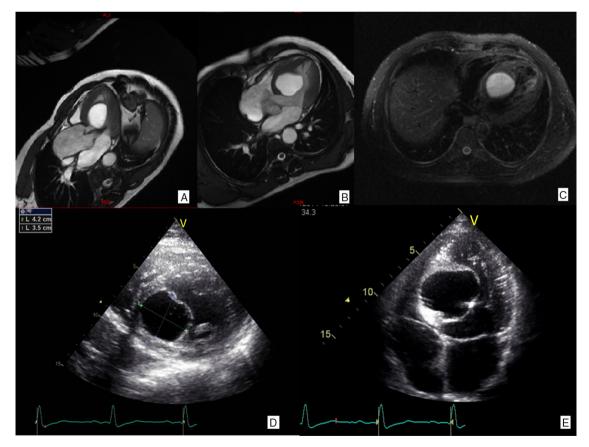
Imaging of the cyst before surgery. (A-C): Magnetic resonance imaging showing the cyst with T2-weighted hyperintense signal; (D and E): transthoracic echocardiogram showing the location of the cyst in the interventricular septum and anechogenic appearance.
